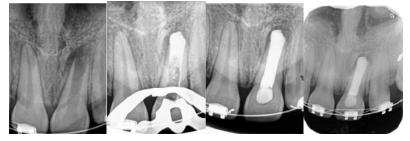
(a) Preoperative radiography(b) Induction of apical plug(c) Canal obturation(d) 2 year follow up.
